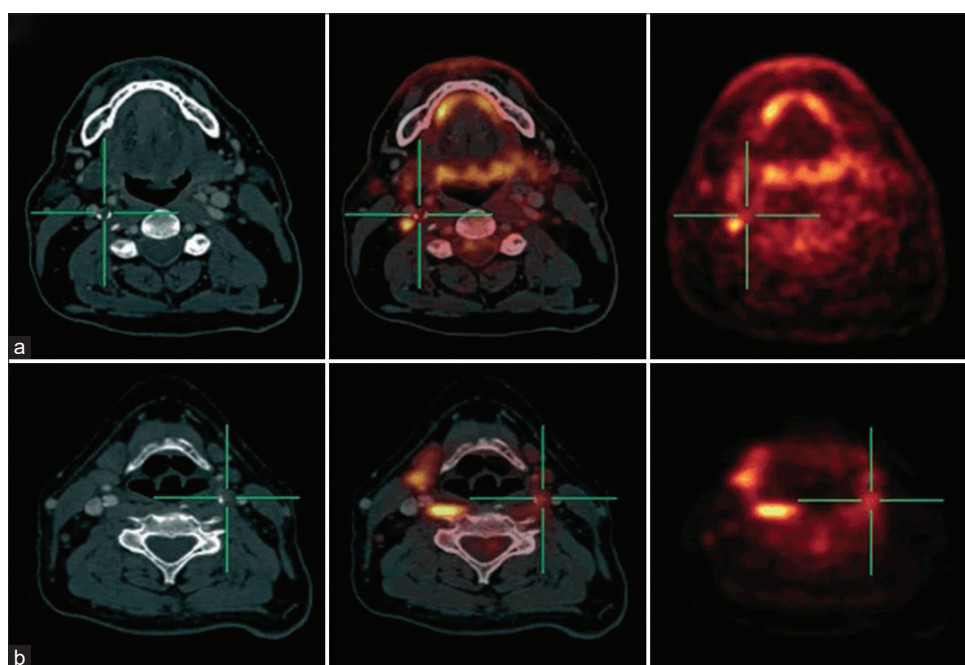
Contrast-enhanced computed tomography (left), fused positron emission tomography/computed tomography (middle) and positron emission tomography alone (right) in patients with symptomatic carotid artery stenosis. Right-sided carotid artery stenosis with vessel wall calcifications and mild ^{18}F -FDG uptake (a). Note the normal physiological uptake in salivary glands. Left-sided carotid plaque with moderate ^{18}F -FDG uptake (b). Note the dense physiological uptake in the right longus capitis muscle and parotid gland
